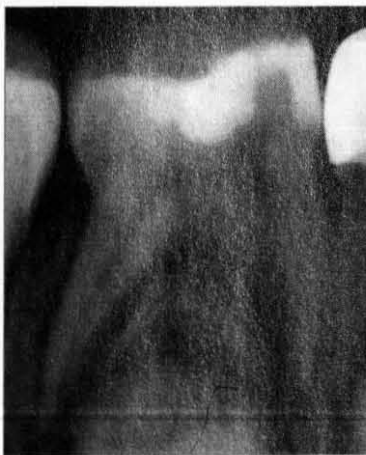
Initial periapical radiograph showing a furcation radiolucency.
